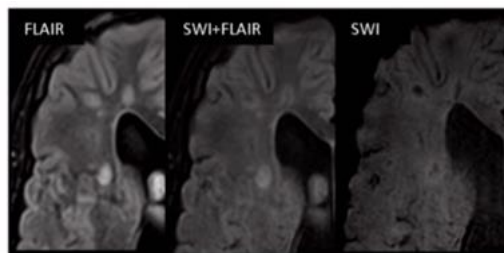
Overlay of SWI and FLAIR using 3D-slicer
